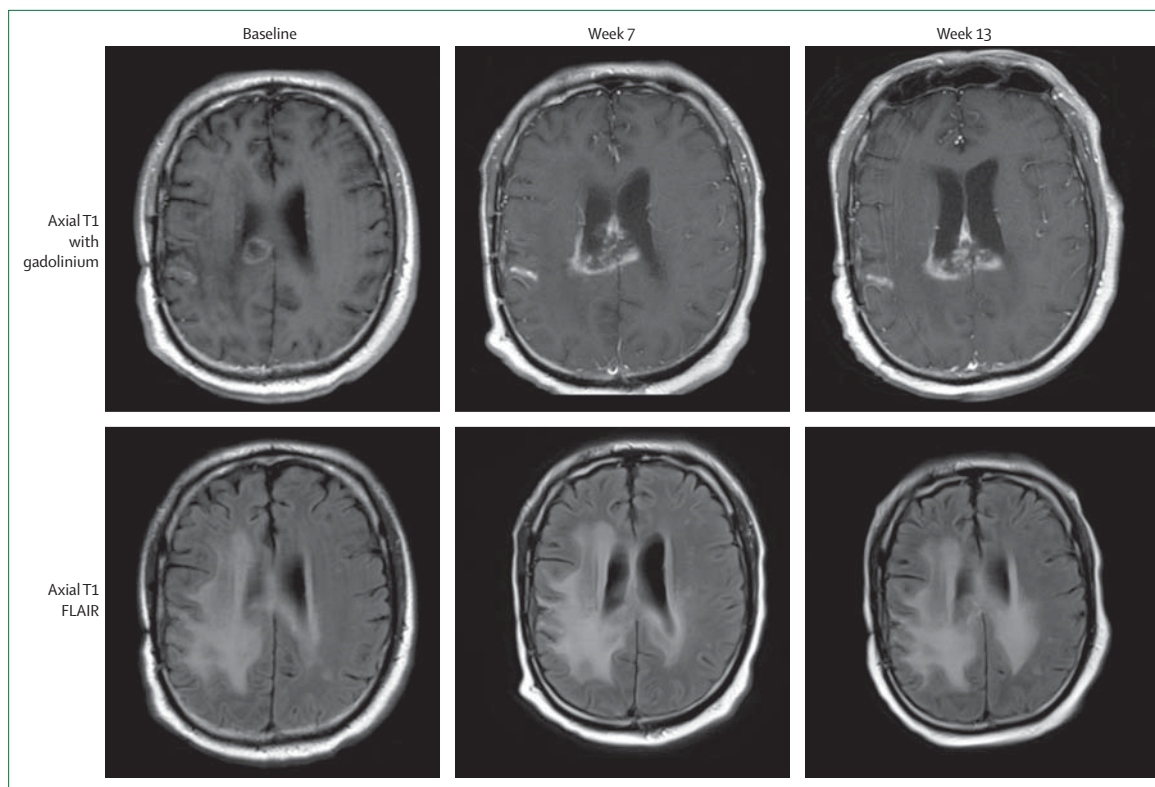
Axial T1 contrast gadolinium-enhanced and FLAIR images before initiation of CTLA-4 immune checkpoint blockade 7 and 13 weeks after therapy.³⁵ Although progressive findings were noted at week 7, imaging at week 13 revealed stable disease. Clinically, the patient remained stable and corticosteroid dosing remained stable at 2 mg once a day. FLAIR=fluid-attenuated inversion recovery.
